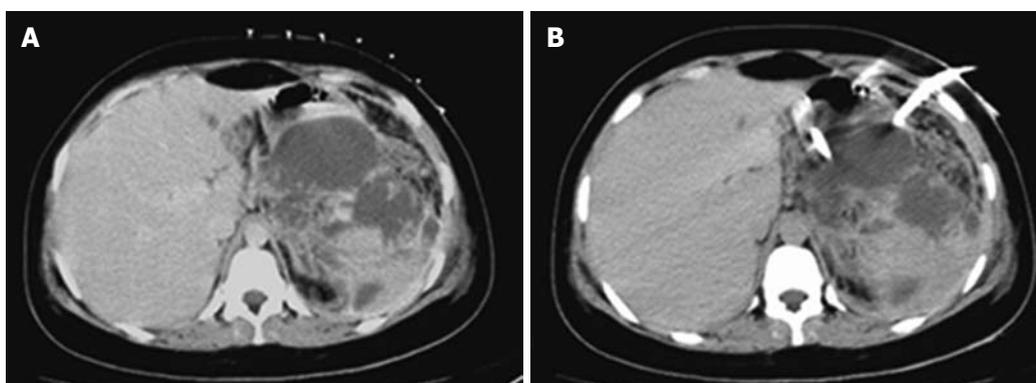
A case of pseudopancreatic cyst secondary to biliary pancreatitis. A: Computed tomography (CT) scan shows a large multilocular pseudopancreatic cyst with localized skin grid seen over the skin before the drainage procedure; B: CT-guided drainage catheter seen within the cavity of the pseudopancreatic cyst.
